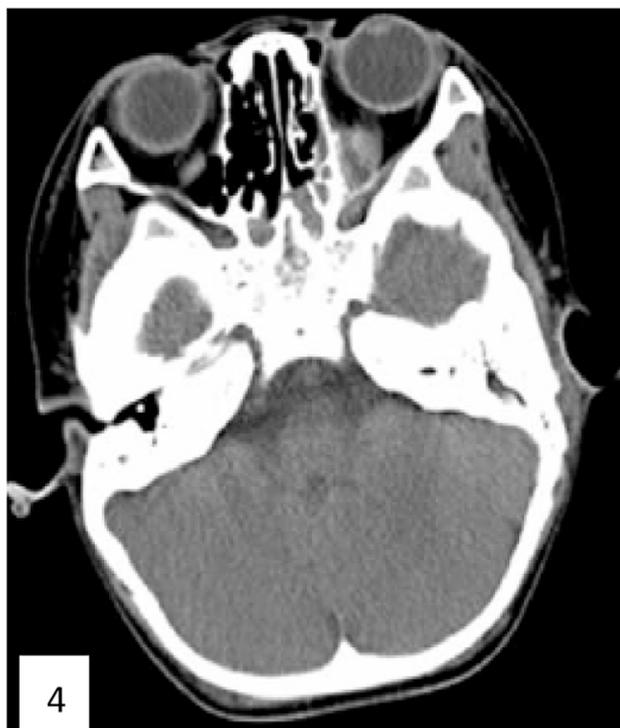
Sinus CT showed soft tissue density shadows at the left sphenoid sinus and the left temporal apex, which oppressed the eye muscles and optic nerve.
